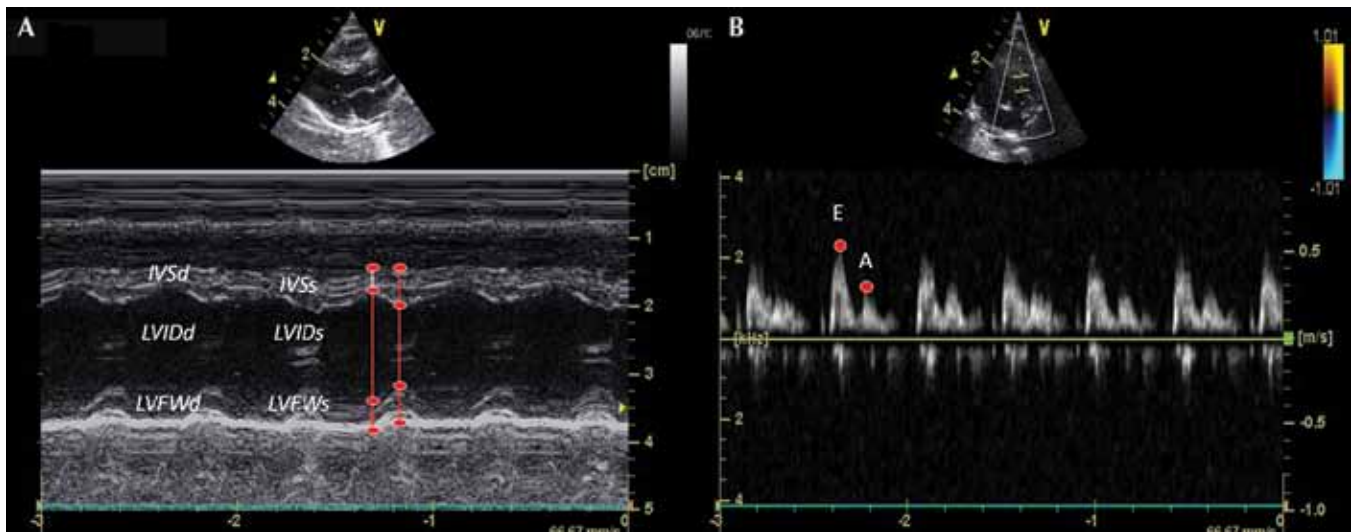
Conventional echocardiographic measurements obtained during the study. (A) Top: B-mode image obtained from parasternal long-axis view. Bottom: M-mode across RV and LV, with measurements of interventricular and free wall thickness in diastole (IVSd and LVFWd, respectively) and systole (IVSs and LVFWs, respectively), left ventricular internal diameter at end-diastole (LVIDd) and end-systole (LVIDs). (B) Top: B-mode image obtained from an apical 4-chamber view. Bottom: Pulse wave Doppler imaging of flow across the mitral valve provides mitral inflow velocity patterns from which peak E and peak A waves and E/A ratio are derived.
